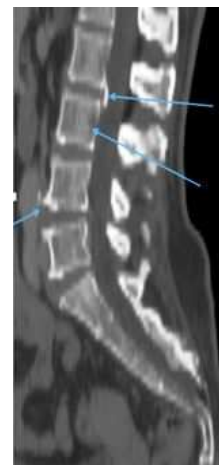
CT scan in the bone window showing stepped arthrosic lesions suggestive of osteophytosis, calcification of the yellow ligament in L2 - L3, with moderate bone demineralization compatible with osteoporosis.
